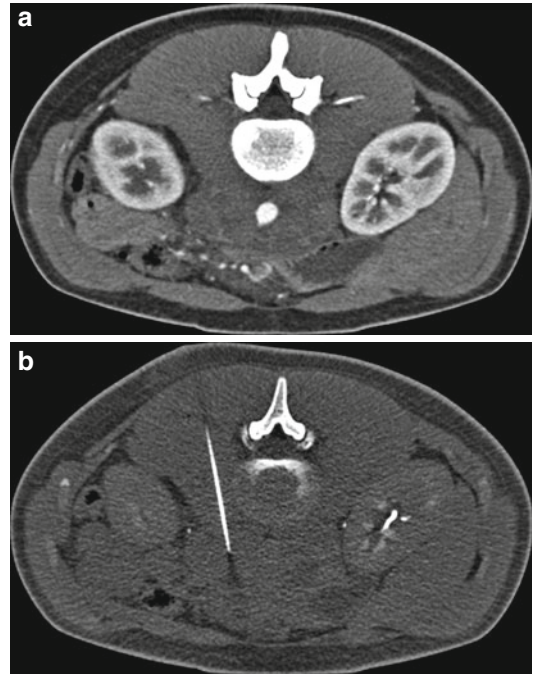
Patient (prone position) with extensive paraaortic lymph node bulking (a). A left posterior paravertebral approach was chosen for aspiration biopsy with a 19-G (15-cm) needle under CT-fluoroscopic guidance (b). Cytology revealed lymph node metastases of an adenocarcinoma
